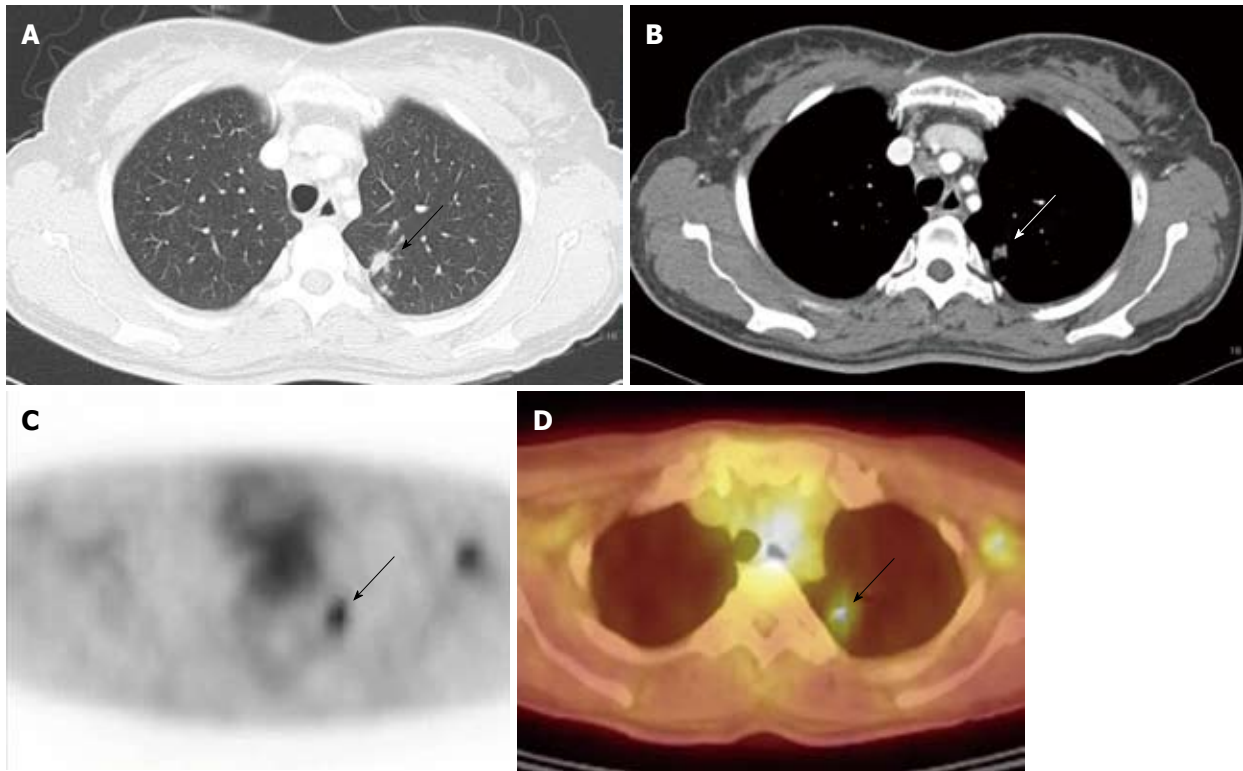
A 51 year-old-female with hepatocellular carcinoma was suspicious of lung metastasis (arrows) in both chest computed tomography and ^{18}F -fluorodeoxyglucose positron emission tomography/computed tomography scan which turned out to be nontuberculosis mycobacterium infection on percutaneous transthoracic needle aspiration. A: High-resolution computed tomography (CT); B: Contrast-enhanced CT; C: ^{18}F -fluorodeoxyglucose positron emission tomography (^{18}F -FDG PET); D: PET/CT scan.
